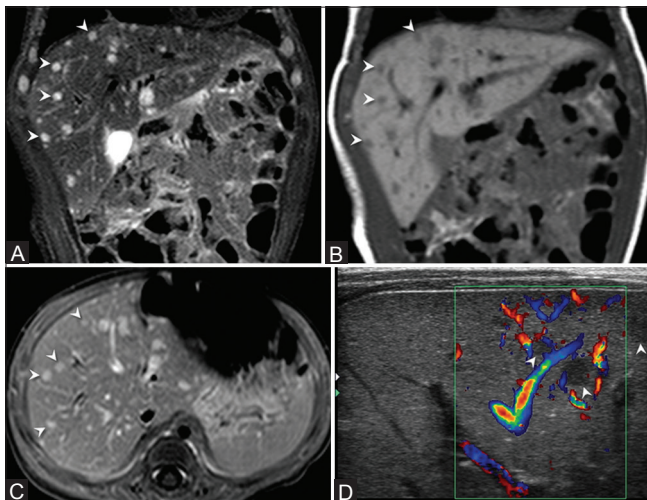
(A-D): Hemangiomas (arrowheads). Multiple small lesions are hyperintense on coronal STIR image (A) hypointense on coronal T1W image (B) and show homogeneous enhancement on post-contrast T1W fat sat image (C) The lesions are hypoechoic on ultrasound color image (D) and show peripheral vascularity
